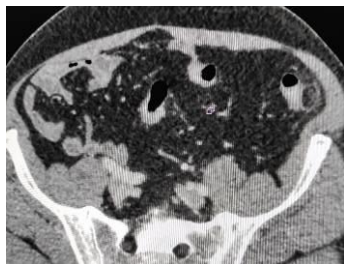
Axial section of an abdominal CT scan without injection of contrast showing an oval lesion of fat density and increased density in surrounding fat planes “ring sign” (arrow)
